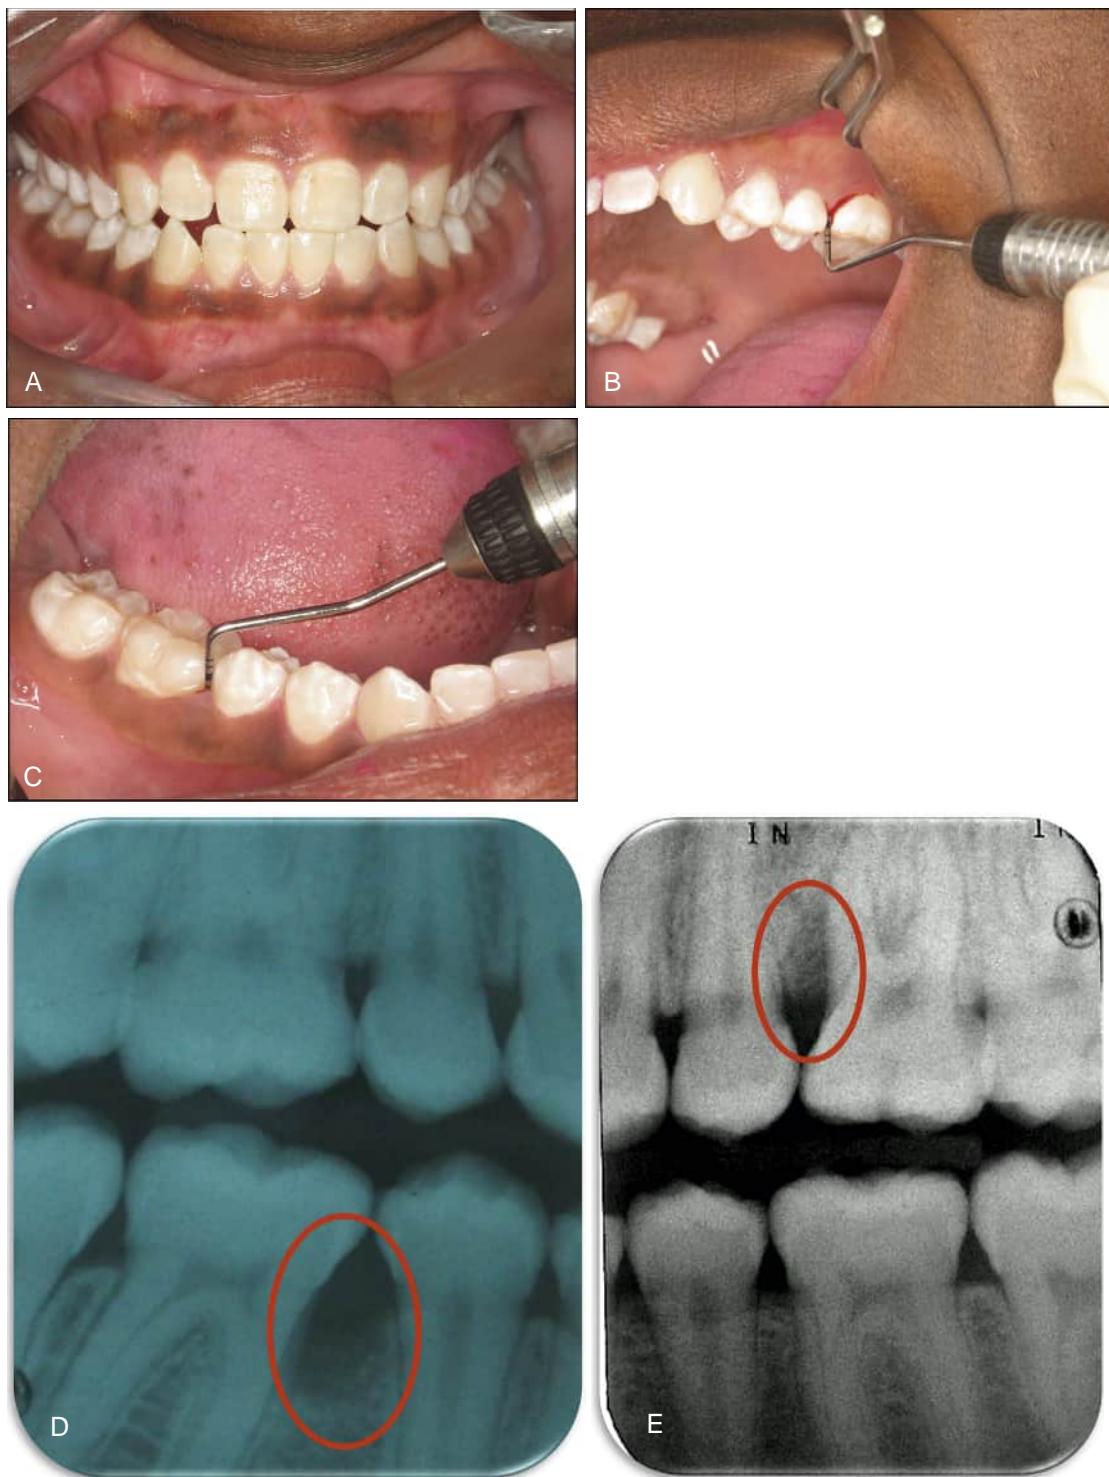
Images of a 15-year-old African American male diagnosed with stage III grade C molar/incisor-pattern periodontitis (previously termed localized aggressive periodontitis, or juvenile periodontitis) in the permanent dentition. (A) View of the patient's smile and apparent clinically healthy gingival tissue. (B) Probing of mesial of upper left first molar showing pocket depth of 8 mm with severe attachment loss and bleeding. (C) Probing of mesial of lower right first molar showing pocket depth of 8 mm with severe attachment loss and bleeding. (D) Radiographic findings revealed a U-shaped pattern (circled) of bone loss adjacent to the lower right first molar. (E) Radiographic findings revealed a vertical (circled) bone loss defect adjacent to the upper left first molar. (Courtesy Dr. Luciana Shaddox)
